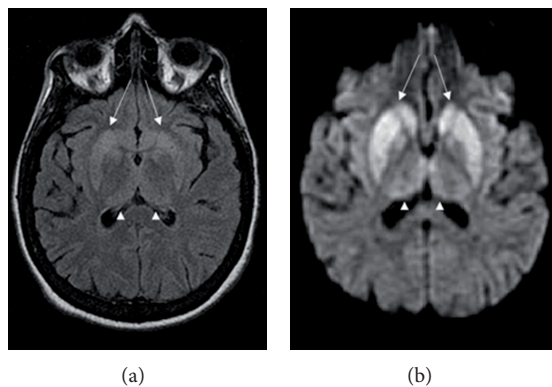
Changes in the basal ganglia seen in CJD. (a) Fluid-attenuated inversion recovery MRI and (b) diffusion-weighted MRI of the same patient demonstrate bilateral basal ganglia hyperintensities (arrows).
